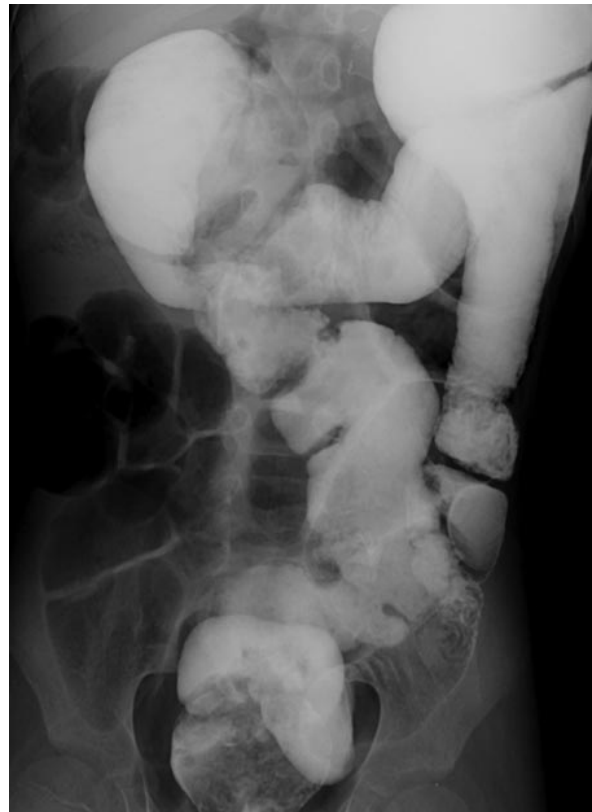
Nonrotation of the bowel. Radiograph shows the presence of iodinated contrast material from an abdominal computed tomographic (CT) examination 1 day earlier. The colon is located primarily in the left side of the abdomen, and the small bowel is in the right side.
